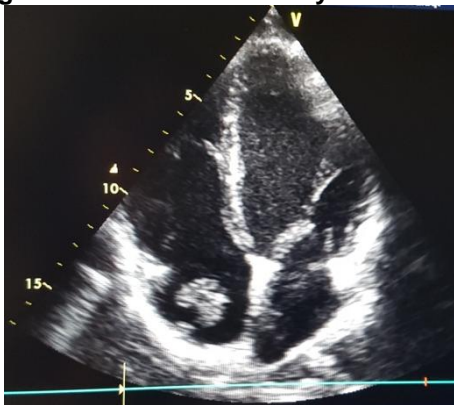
TTE cardiac ultrasound: Cystic formation in the right atrium
